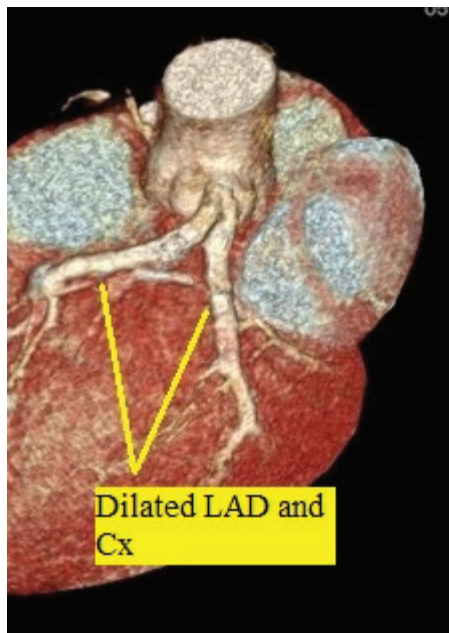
The left coronary artery and left ascending coronary artery of the patient 2 on reconstructed 3D cardiac computerized tomography (CT) scan
